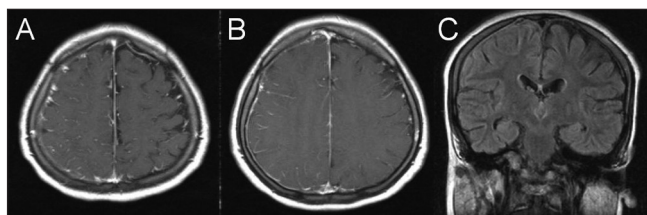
(a, b) Contrast-enhanced axial T1-weighted images showing enhancement of meningeal surface at the right hemisphere. (c) Asymmetrical sulcal involvement seen on the right side on the coronal FLAIR image
